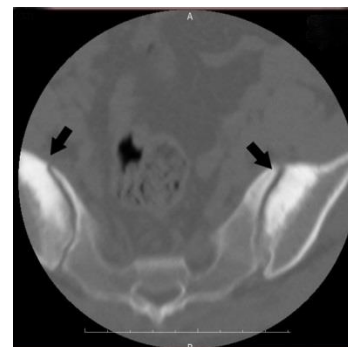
Bilateral osteitis condensans ilii in a 34 year old female patient. Computed tomography shows triangular shaped sclerosis in the inferior part of the bilateral iliac bone adjacent to the both sacroiliac joint (thick arrows).
